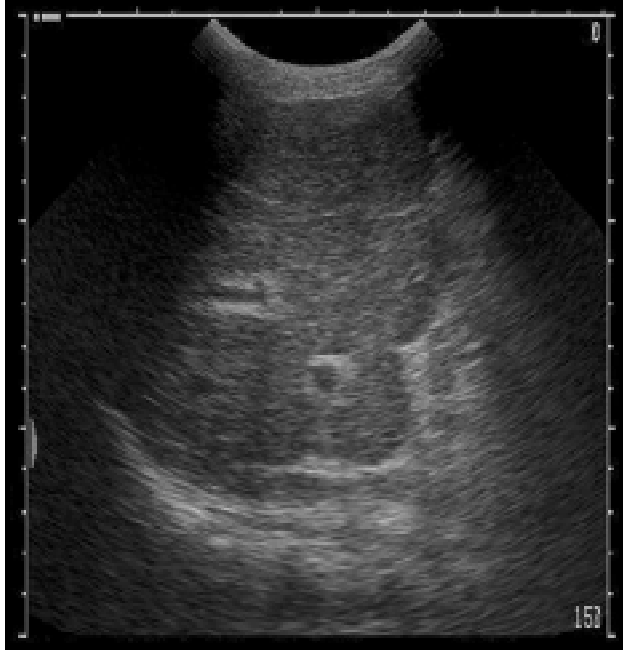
Ultrasound scan showing the right hepatic lobe with evident periportal echogenic thickening, increase in the fiber-like tissue and irregular borders - severe hepatopathy, with alterations compatible with cirrhosis
